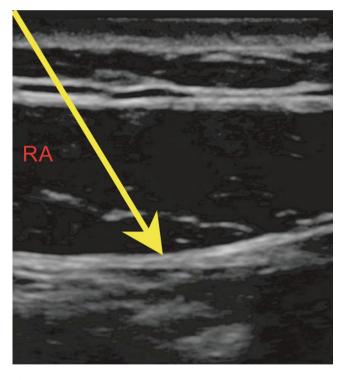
Sonographic image with *arrow* indicating location for local anesthetic placement for rectus sheath block (*RA* rectus abdominis muscle)
